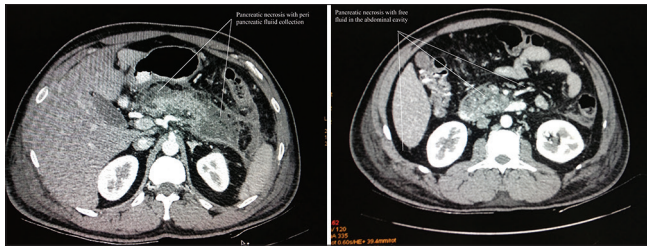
Computed tomography of abdomen showed pancreatic necrosis with peripancreatic fluid collection and peripancreatic fat stranding
